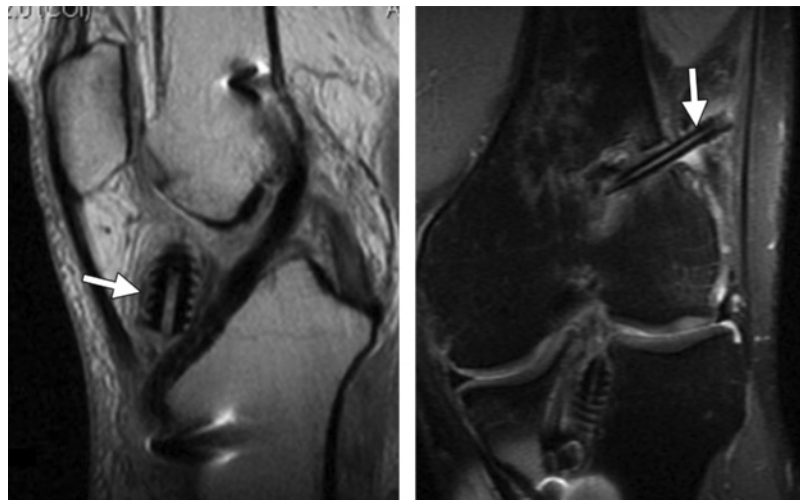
Hardware failure. (a) Sagittal proton-density-weighted fast spin-echo MR image shows a loosened tibial interference screw (arrow). (b) Coronal T2-weighted fast spin-echo MR image shows a loosened and partially dislodged cross pin (arrow) used for femoral fixation in ACL graft reconstruction.
